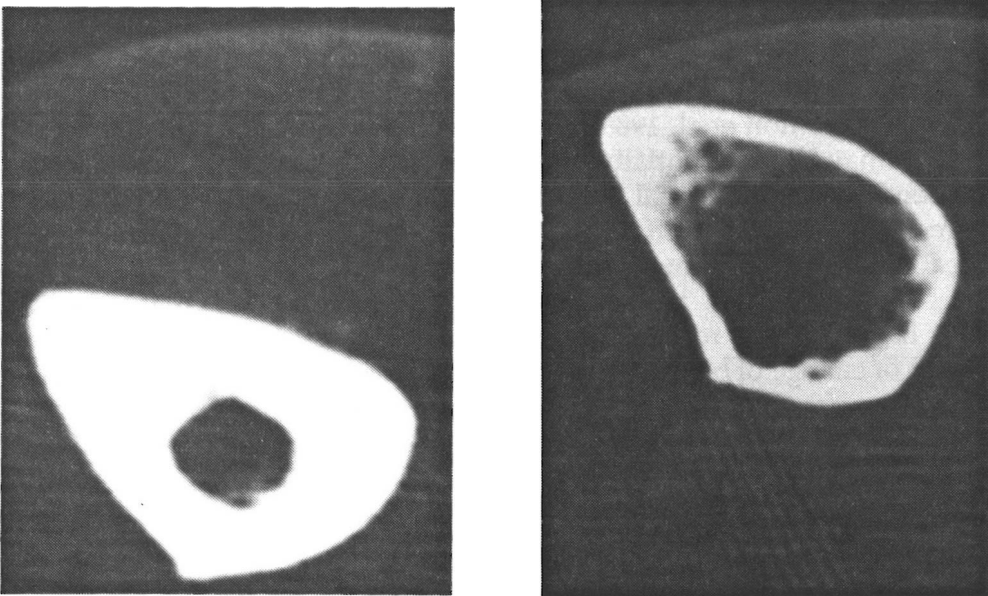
Cross-section of cortical bone in middle shaft of tibia, of women with high BMD (left) and osteoporotic women (right). Image from CT scan.
